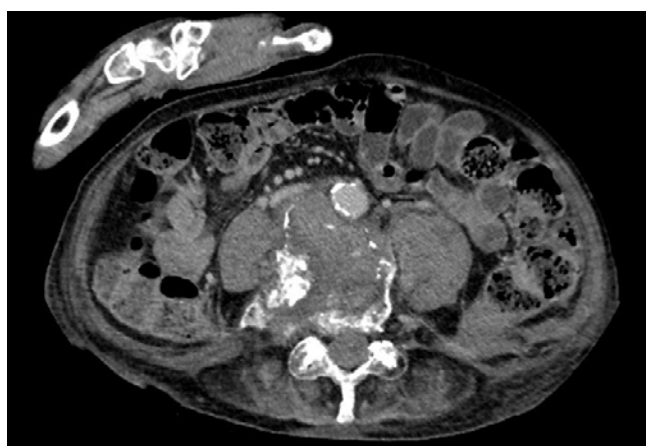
Ten days after the injury, contrast-enhanced CT, axial (fourth lumbar vertebra level).
